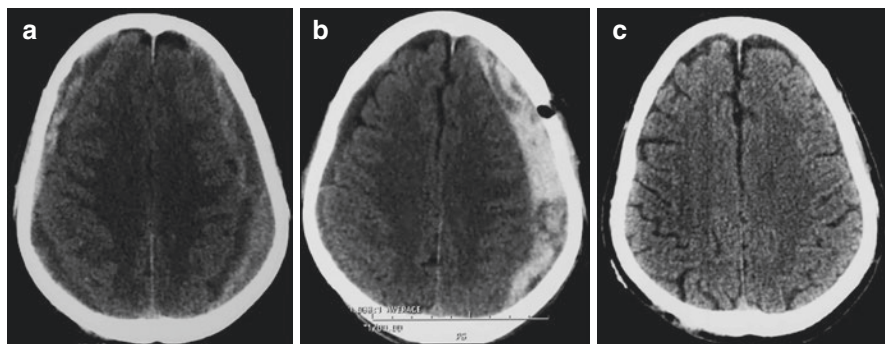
Third day postoperative acute subdural hematoma. The patient was reoperated (Bone flap craniotomy) with a good outcome. Initial axial cranial CT scan (a), on the third postoperative day (b), and 3 months later (c)
